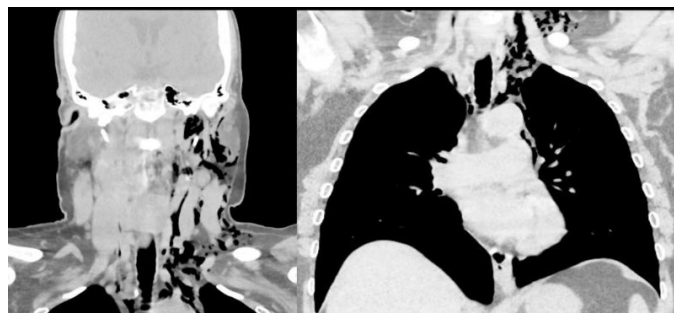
Computed tomography demonstrates air tracking into the mediastinum
